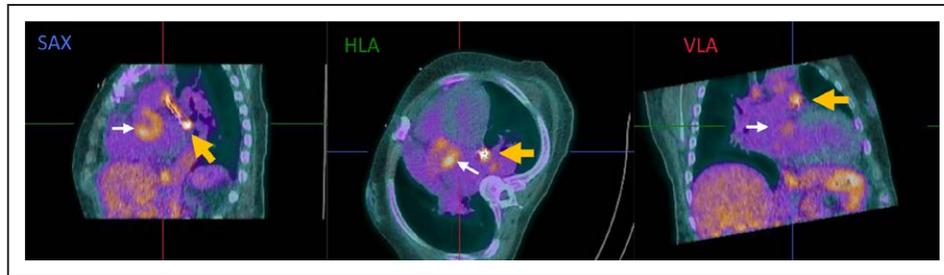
Short axis (SAX, left), horizontal long axis (HLA, middle), and vertical long axis (VLA, right) hybrid ^{18}F -fluorodeoxyglucose (FDG) positron emission tomography/computed tomography (PET/CT) fusion images demonstrating intense FDG uptake surrounding AtriClip device (thick yellow arrows) and aortic annulus (thin white arrows). FDG uptake in mediastinal lymph nodes is also seen.
